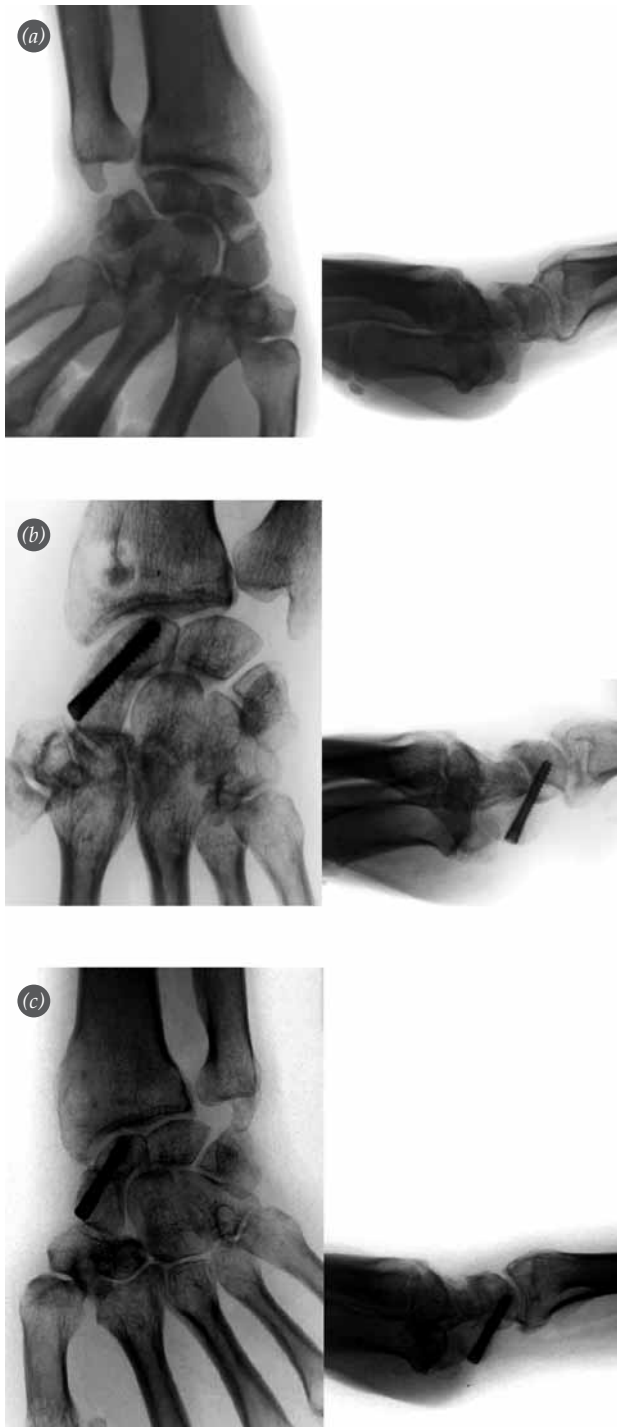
Case 3. 34-year-old male admitted to our clinic with progressive complaints persisting for 8 months following a trauma of the right wrist. (a) Bilateral radiographs showing non-union located in the scaphoid waist, manifesting itself by cystic changes (Slade Grade 5). (b) Postoperative bilateral radiographs showing the carpal alignment and scaphoid bone morphology restored by application of a cancellous graft, harvested from the distal metaphyseal region of the radius and headless screws. (c) 12th week radiographs showing union and carpal alignment in the normal range.
